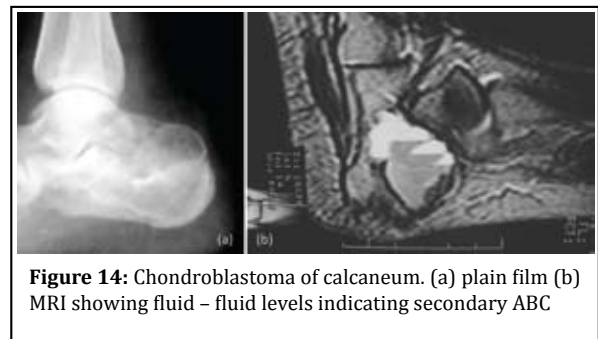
Chondroblastoma of calcaneum. (a) plain film (b) MRI showing fluid - fluid levels indicating secondary ABC
